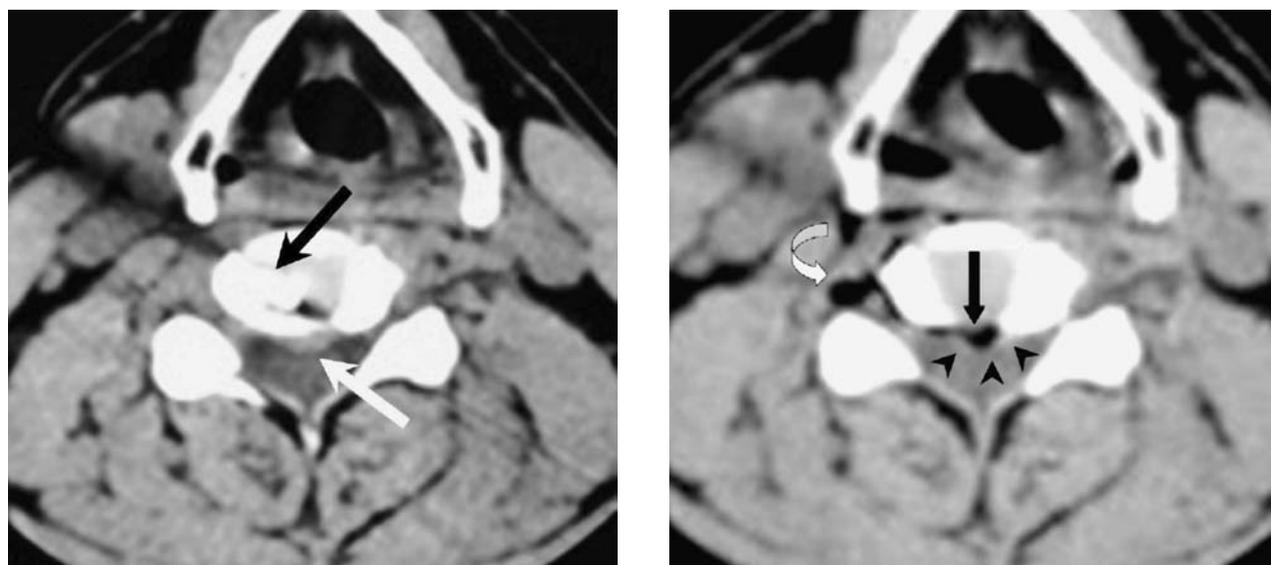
Images in a patient with C4-C5 midline disk herniation (myelopathic type). A) Precontrast CT image at the C4-C5 level shows disk herniation (*white arrow*): the needle (*black arrow*) into the disk before ozone injection. B) After ozone injection, CT shows ozone dispersion into the herniated disk material (*black arrow*) with local intact annulus fibrosus (*black arrowheads*). After intradiscal injection, ozone is injected into the paraspinal tissue (*white curved arrow*).
